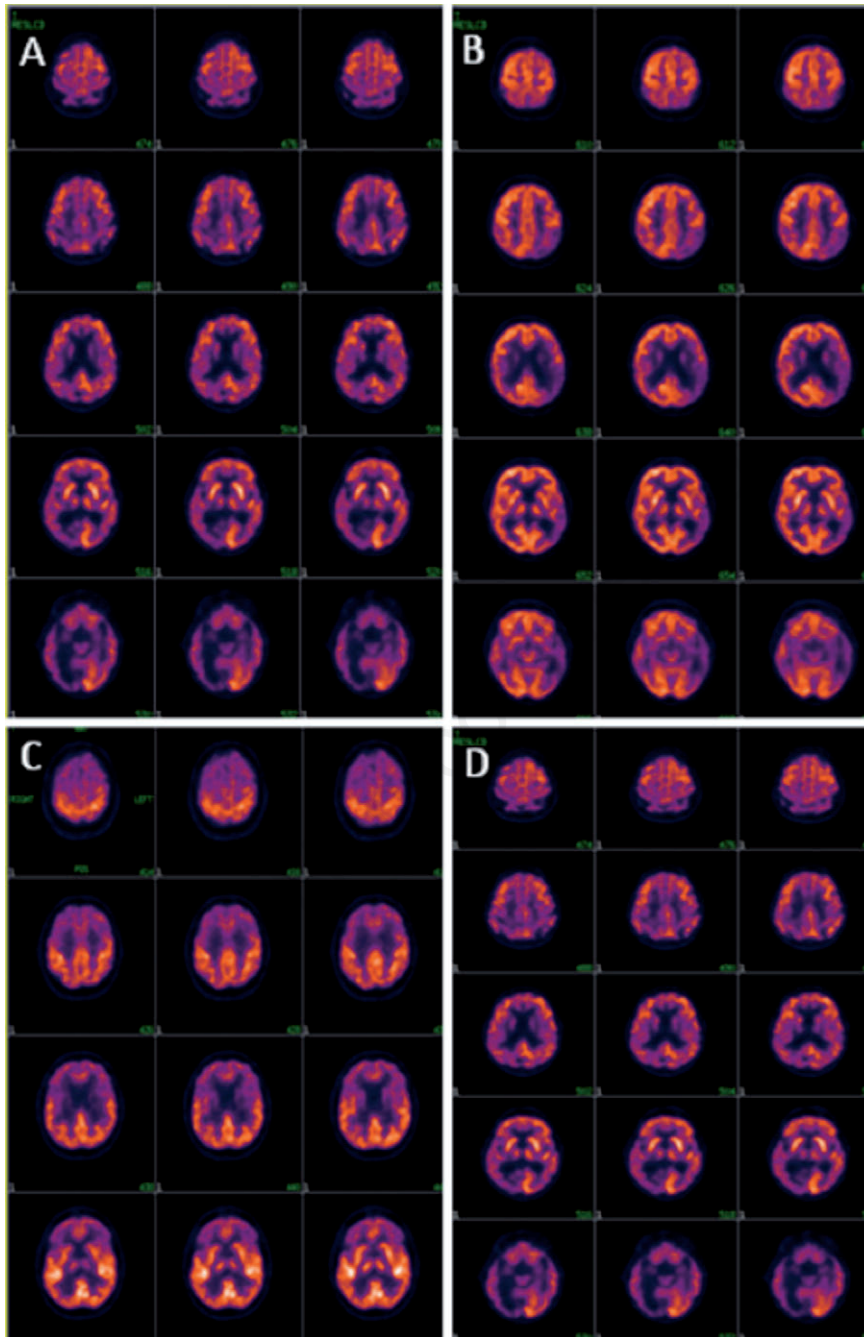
Trasversal slices of brain ^{18}F -Fluorodeoxyglucose positron emission tomography-computed tomography in various neurodegenerative conditions: A) mild cognitive impairment; B) Alzheimer's disease; C) fronto-temporal dementia; D) Lewy-bodies dementia.
